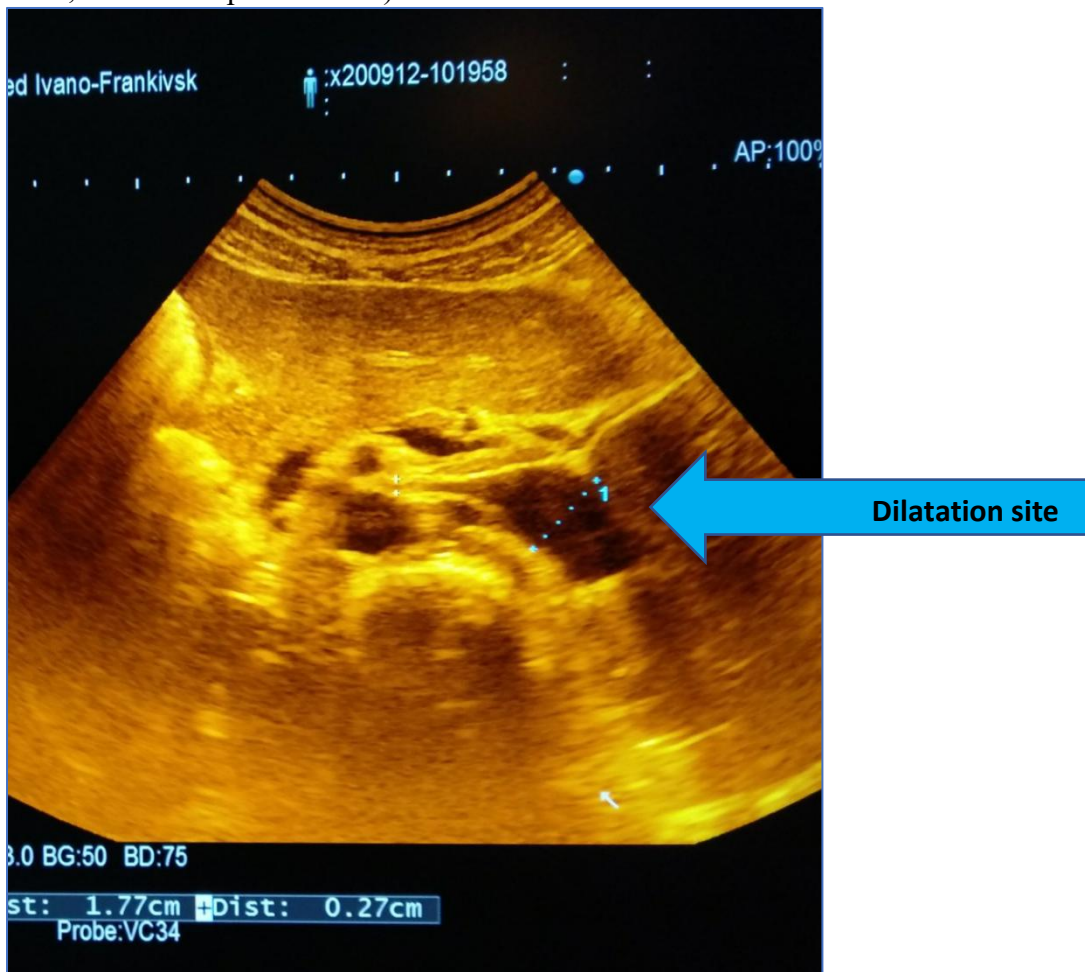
Ultrasound pattern of “the nutcracker syndrome” (B - mode).
